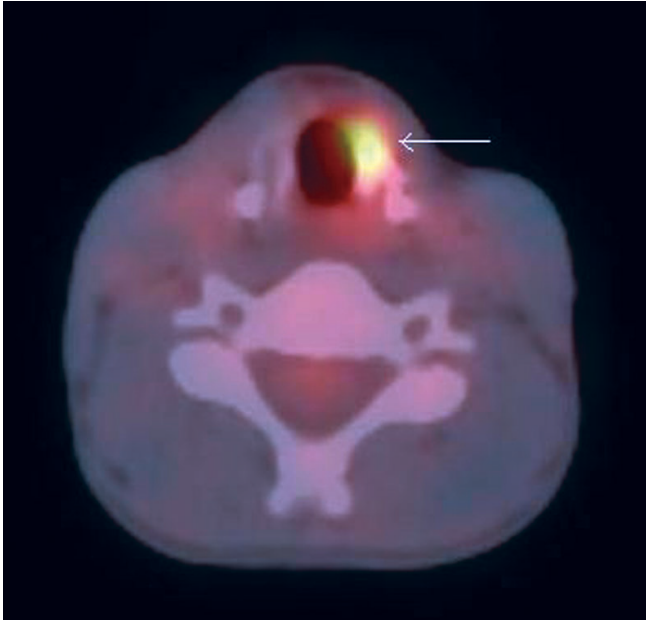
Coregistered transverse PET-CT fusion image of the neck shows increased FDG uptake (white arrow) in the left intrinsic laryngeal muscles (vocal cord).
